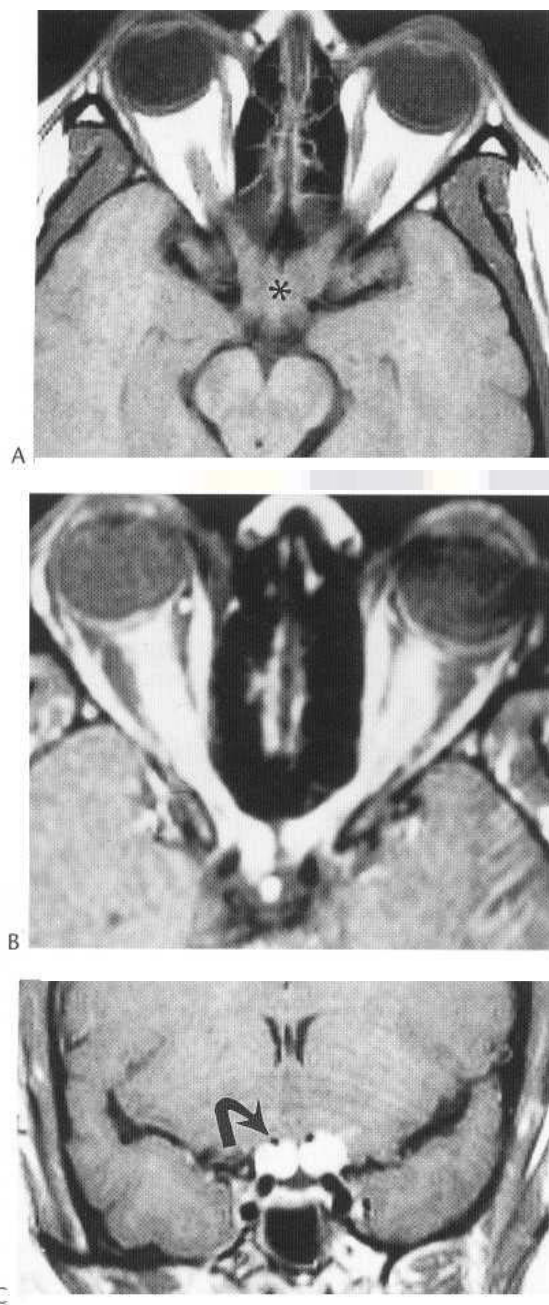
Sarcoidosis. Axial T₁-weighted MR image (A) demonstrates thickening of optic nerves and chiasm (asterisk). Fat-saturated contrast-enhanced axial (B) and coronal T₁-weighted enhanced (C) images demonstrate marked enhancement of the optic nerves and chiasm.
